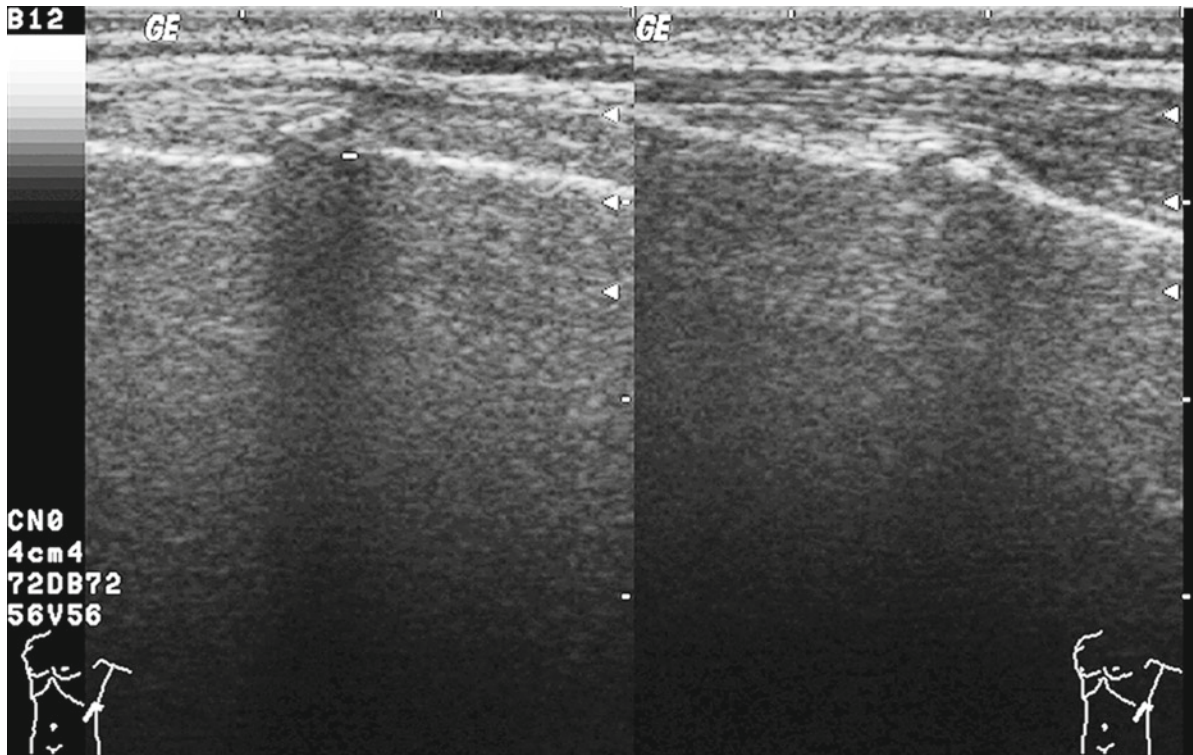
Rib fracture with a step of 1.5 mm. This fracture could not be seen on X-rays. No accompanying hematoma above the fracture site
